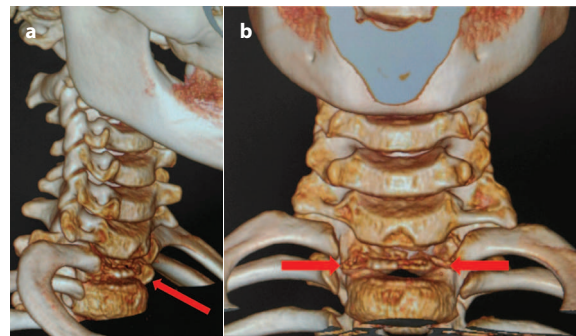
3-D computed tomography (CT) reconstructed images (oblique and coronal view) showing the T₁ vertebra flattening (red arrows), at the level of first pair of thoracic ribs.
